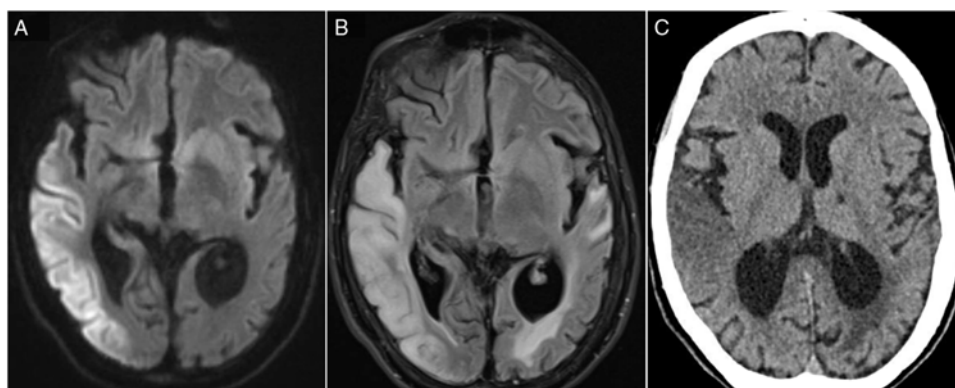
(A) DWI hyperintensity affecting right temporal, parietal and occipital cortices. (B) Corresponding T2-FLAIR hyperintense lesions with additional vasogenic oedema. (C) The same lesion on a CT scan.
